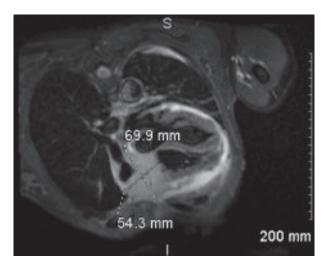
Pre chemotherapy cardiac MRI.
